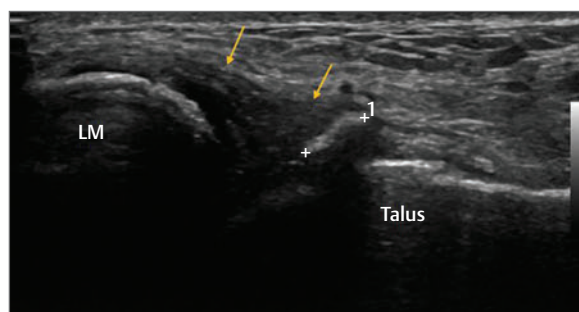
Longitudinal image of the anterior talofibular ligament (yellow arrows). The image demonstrates thickening of the ligament which is of poor echogenicity. In addition, there appears to be a bony fragment (white crosses) to the left of the talus measuring approximately 5 mm. Dynamic stressing of the ligament demonstrated a negative sonographic draw. These findings are in keeping with a partial tear of the anterior talofibular ligament with associated avulsion fragment from the talus.
